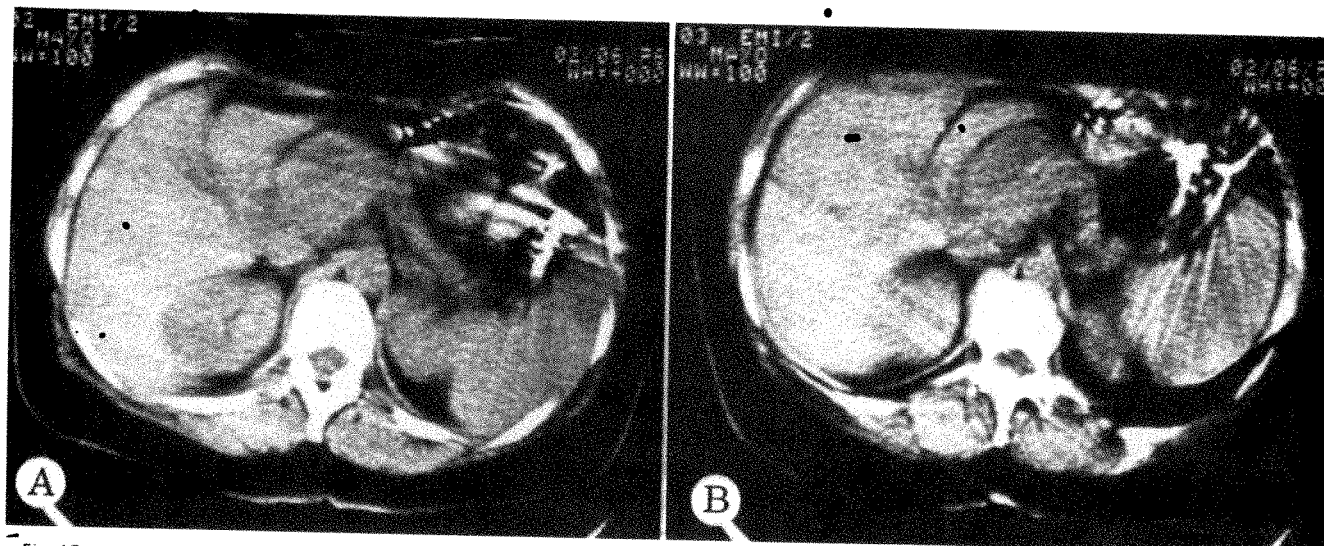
CT scans of 49-year-old woman with 5 month history of abdominal pain and weight loss. A, Large mass in head of pancreas; tail normal size. B, In addition to pancreatic mass, several low density metastatic lesions present in anterior portion of right lobe of liver. Large carcinoma of head and body of pancreas confirmed at surgery, and multiple hepatic metastatic lesions 1 and 2 cm in diameter found. (Mass also clearly outlined at time of gray-scale ultrasound examination.)
